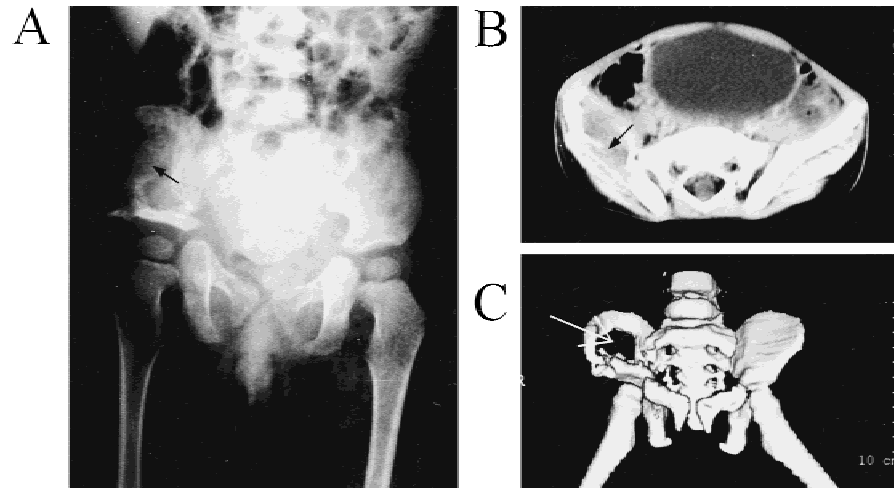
Damage of the right iliac bone. (A) LCH involving the right iliac bone was shown by X-ray; (B) CT image showed the soft tissue mass (arrow); (C) A three dimension of CT image showed the damage of the right iliac bone (arrow).
